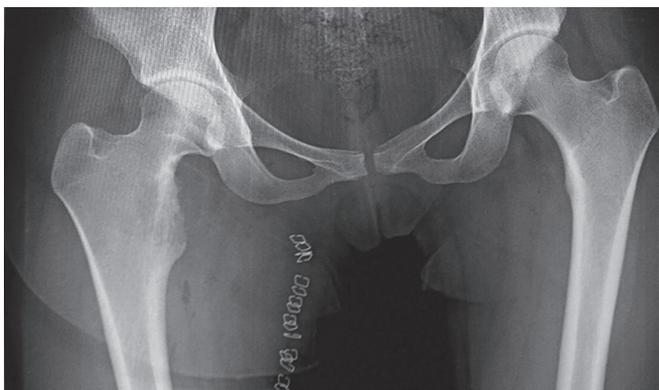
Postoperative X-ray of bilateral hip with upper thigh – anteroposterior view
